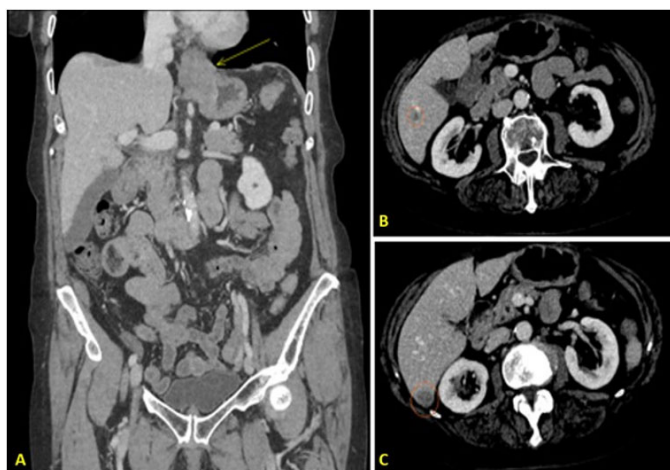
CT Dec 2022 showing large gastro-esophageal junction mass (A) and hepatic metastases (B, C).
